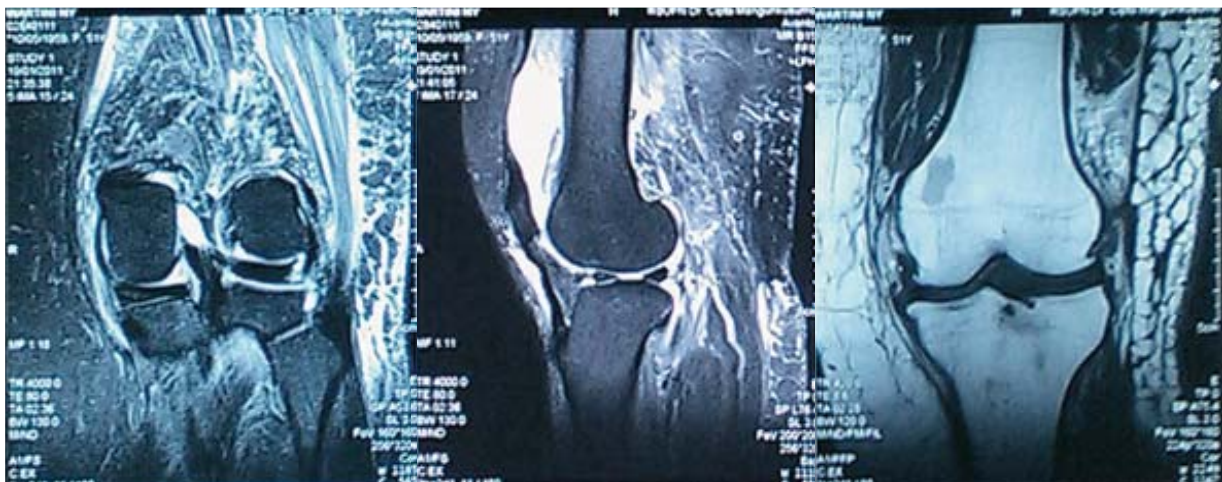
Magnetic resonance imaging of the left knee, showing degeneration of medial meniscus (A), accumulation of synovial fluid (B), and formation of osteophytes on medial epicondyle of femur, medial and lateral epicondyle of tibia, and intercondylar eminence (C).
